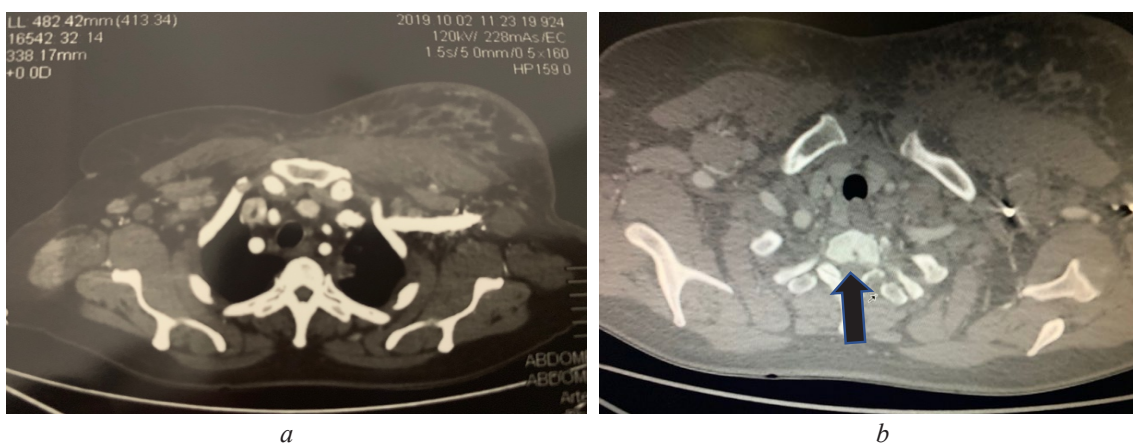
Computed tomography: *a* – left breast invasion with a malignant mass and extensive lymphadenopathy; *b* – with metastatic deposits on the thoracic vertebral body
